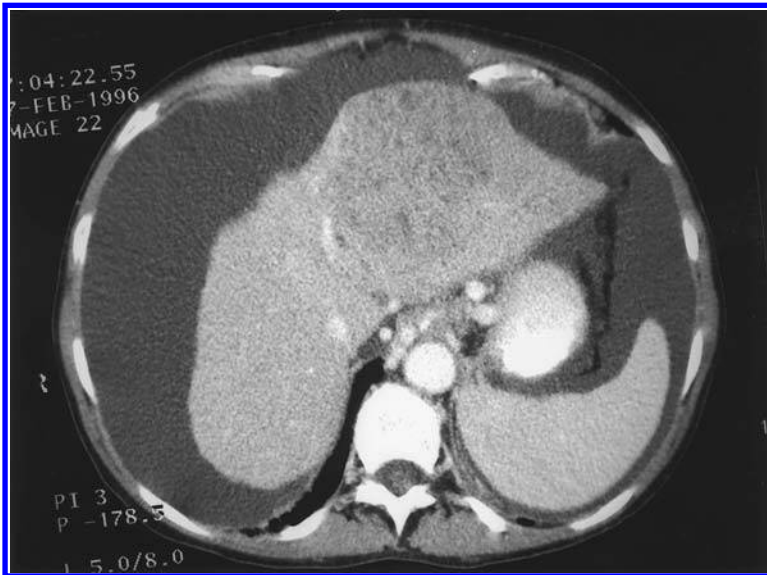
Computed tomography of liver demonstrating hepatocellular carcinoma in left lobe, as well as cirrhosis and ascites.
